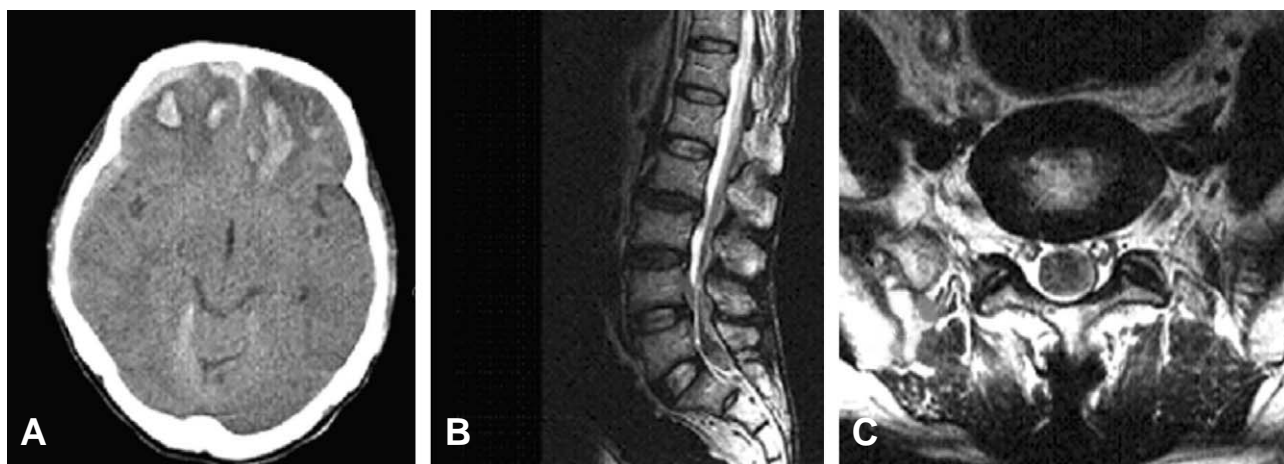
(A) Computed tomography scan of the brain reveals both frontal hemorrhagic contusion and subdural hematoma, (B, C) Sagittal and axial T2-weighted magnetic resonance images show massive hypointensive lesions from L4 to S1 within the dural sac.
